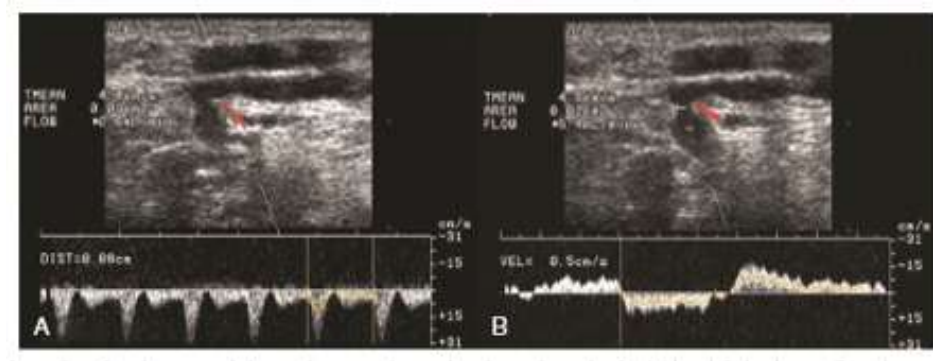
A, A small perforating artery is located next to the perforating vein at the fascial level. Pulsed wave Doppler confirms arterial. B, Doppler signal from the incompetent perforating vein indicates bidirectional flow (*Lurie, 2014*).
